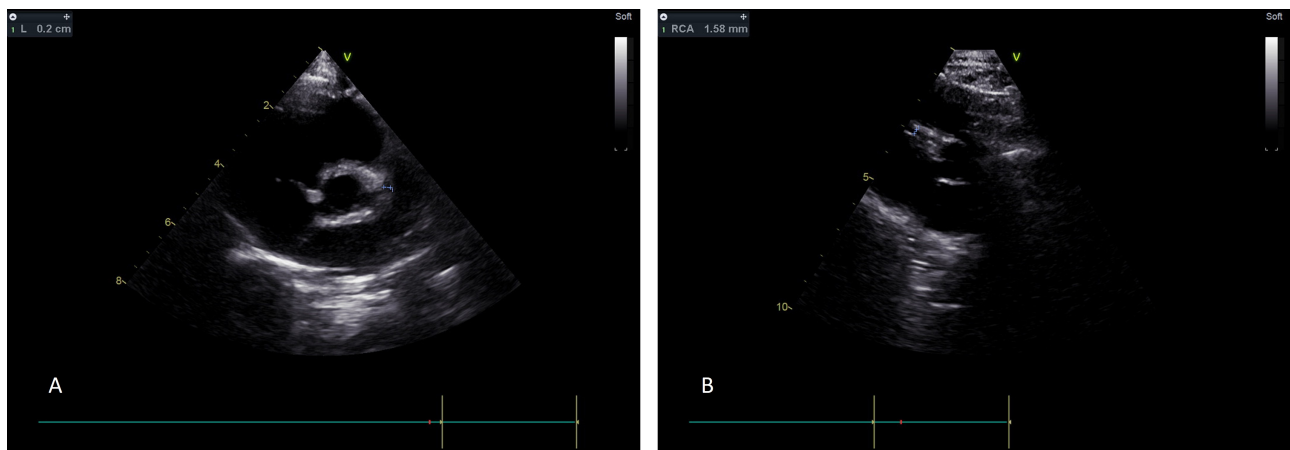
Echocardiogram one year later showing full resolution of the aneurysms. (A) The LCA aneurysm has fully resolved. (B) Similarly, the RCA now has a normal diameter. LCA: left coronary artery; RCA: right coronary artery.
